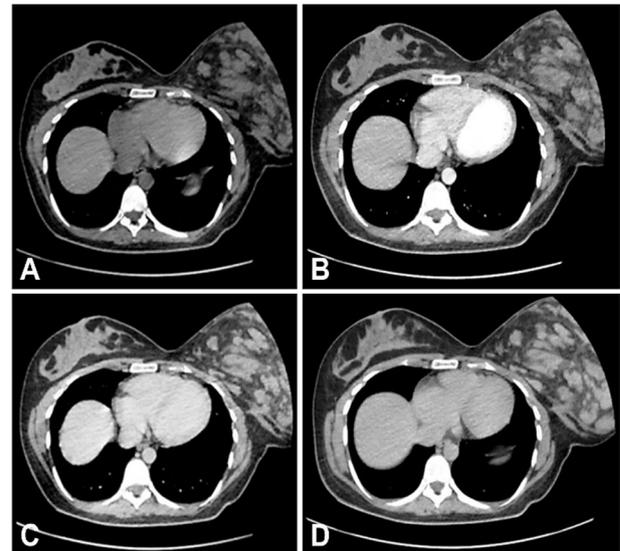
Chest computed tomography (CT) showing enlarged left breast exceeding the acquiring possibilities of the imaging equipment. The normal mammary parenchyma was undetectable, being replaced by multiple images with different inhomogeneous densities. Different level images suggesting insular infiltration of the subcutaneous tissue and prethoracic plane. (CT is not adequate for proper breast disorders evaluation).
